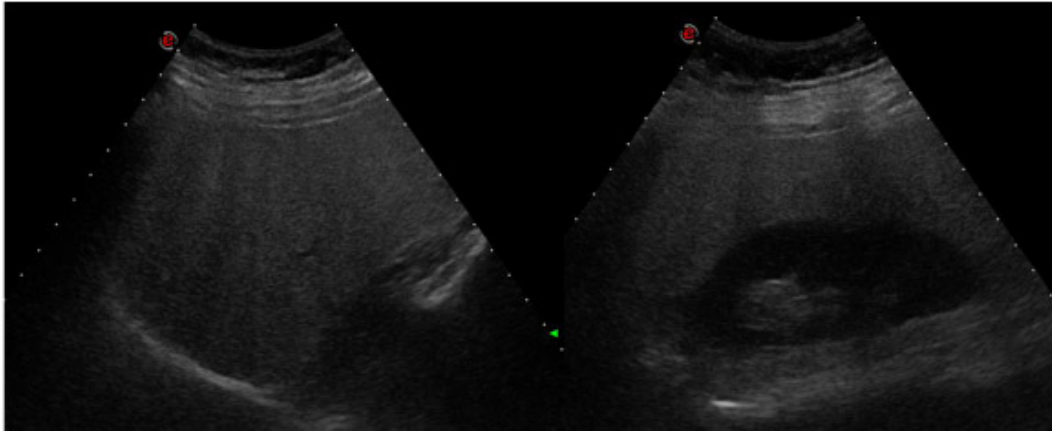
On ultrasound image severe fatty infiltration of the liver cause pronounced attenuation of sound waves. The echogenicity of the liver is more higher than that of the kidney.
